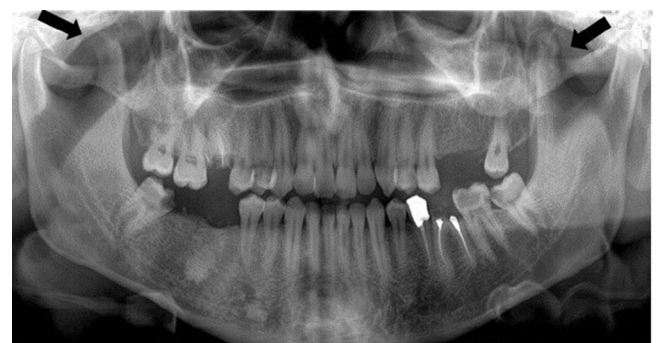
Panoramic radiography: the arrow indicates bilateral coronoid process hyperplasia.
